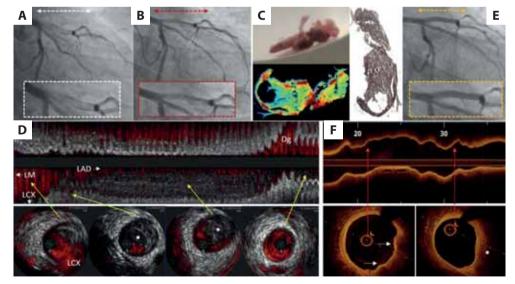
Multimodality assessment of the patient with ST-segment myocardial infarction successfully treated with a non-stenting strategy. Baseline coronary angiography with haziness in the proximal left anterior descending artery (A) and angiography after thrombectomy (B). C. Aspirated thrombus with results of Fourier and Raman Spectroscopy. D. Intravascular ultrasound imaging with a plaque in the proximal part of the LAD covered by thrombus protruding to the medial LAD (asterisk). E. Control angiography and optical coherence tomography (F) with a thrombus (arrow) and lipid plaque (asterisks)
